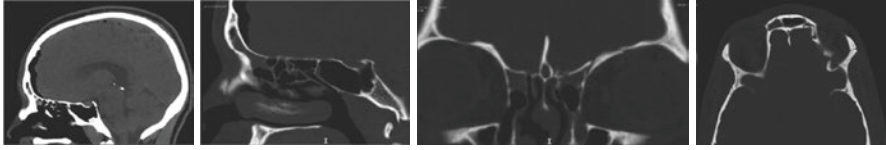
Noncontrast CT head demonstrated pneumocephalus (left image) and skull base fractures (right three images) in a patient with CSF leak following assault
